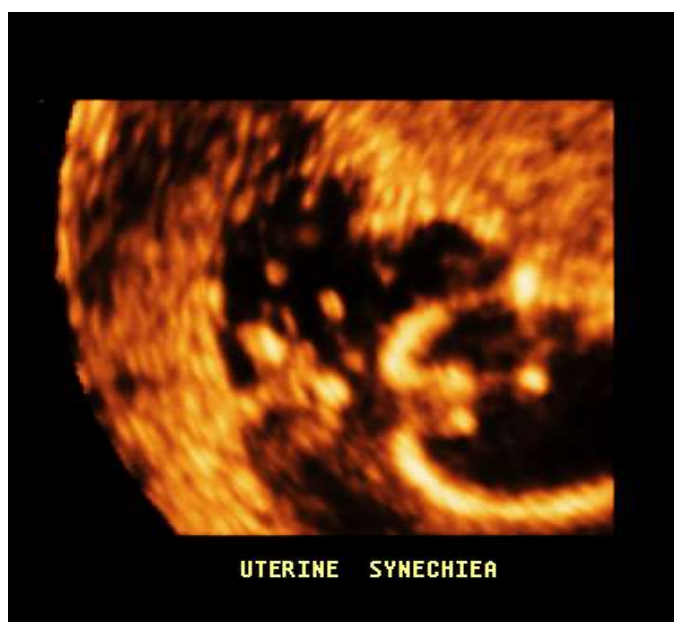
3D ultrasound surface rendering of severe endometrial cavity adhesions
